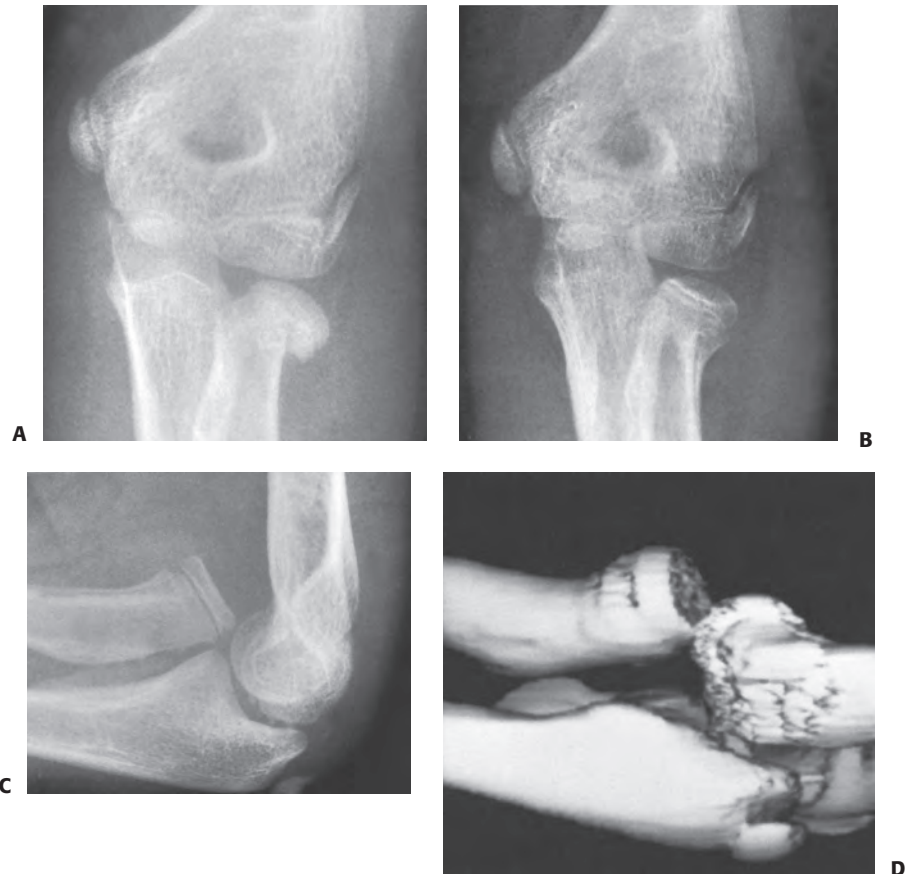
Angulation. A: Injury film showing 30 degrees of angulation and 30% lateral translocation of a radial neck fracture in a 10-year-old. B: Radiograph appearance of the proximal radius taken about 5 months later, showing lateral angulation of the neck. C: Lateral view showing the anterior relationship of the radial neck with proximal migration. At this point the patient had full supination and pronation but a clicking sensation with forearm rotation in the area of the radial head. D: Three-dimensional reconstruction showing the incongruity of the proximal radiocapitellar joint. (Courtesy of Vince Mosca, MD.)
